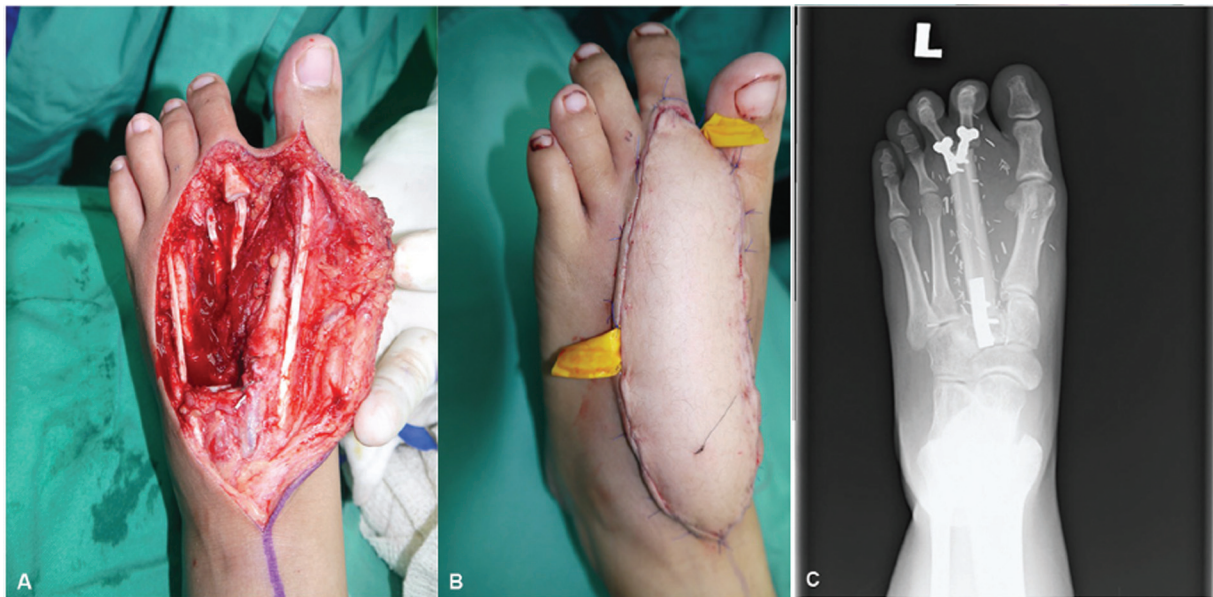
The reconstruction with free fibula osteocutaneous flap. The patient's left foot was reconstructed with a free fibula flap following oncological resection of the tumor. (A) The defect after tumor resection, measuring $8 \times 8 \times 4$ cm. (B) The immediate postoperative flap appearance. (C) The flap's osseous configuration as shown in an X-ray.
